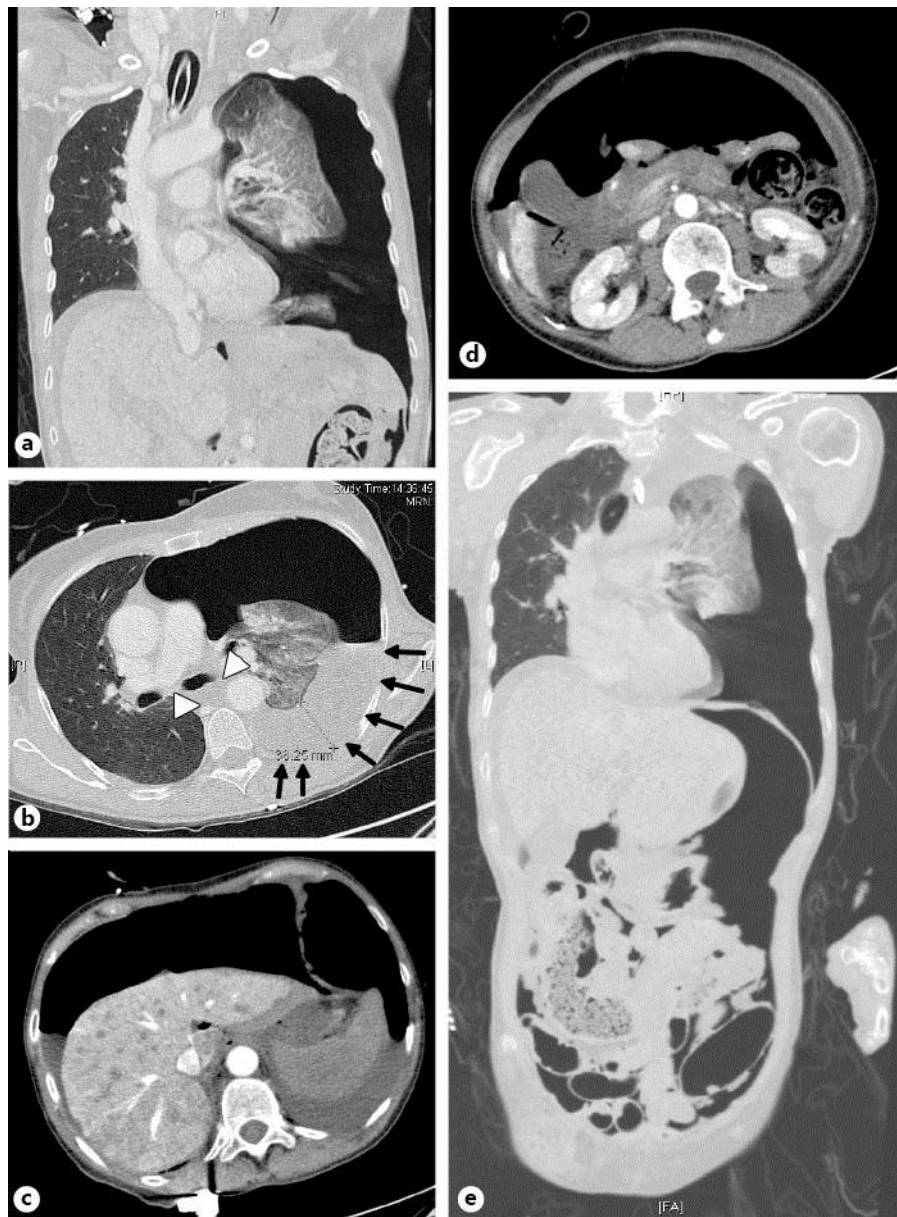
CT scan of the chest and abdomen demonstrated tension pneumothorax (a, b), necrotic esophagus (b, white arrowheads), necrotic pleural effusion (b, black arrows) and gastrointestinal perforation with free air in the abdominal cavity (c, d). e Frontal reconstruction of the CT scan.
